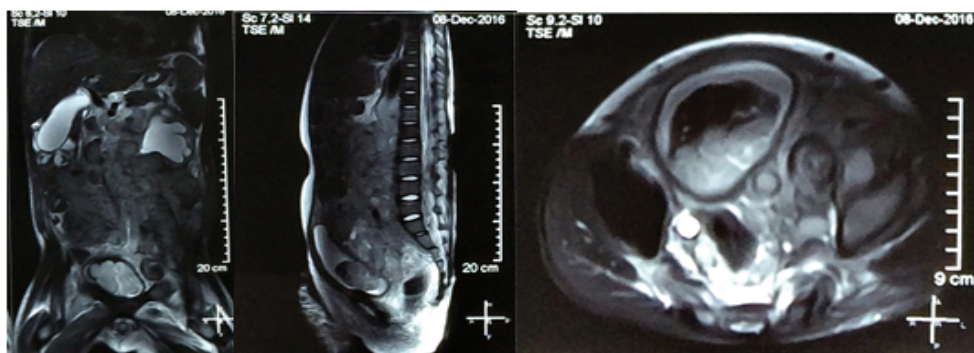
MRI: there are solid mass of malgina bladder with extension from serosa to perivesica accompanied with lymphadenopathy causing bilateral severe hydronephrosis.
